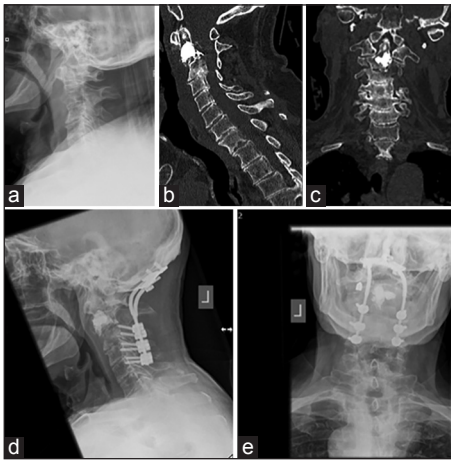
Images from Patient 1. Pre-operative lateral radiograph of the cervical spine (a). Persistent instability was felt to be present despite vertebroplasty on reviewing the CT (b and c) so surgical stabilization was elected (d and e)
